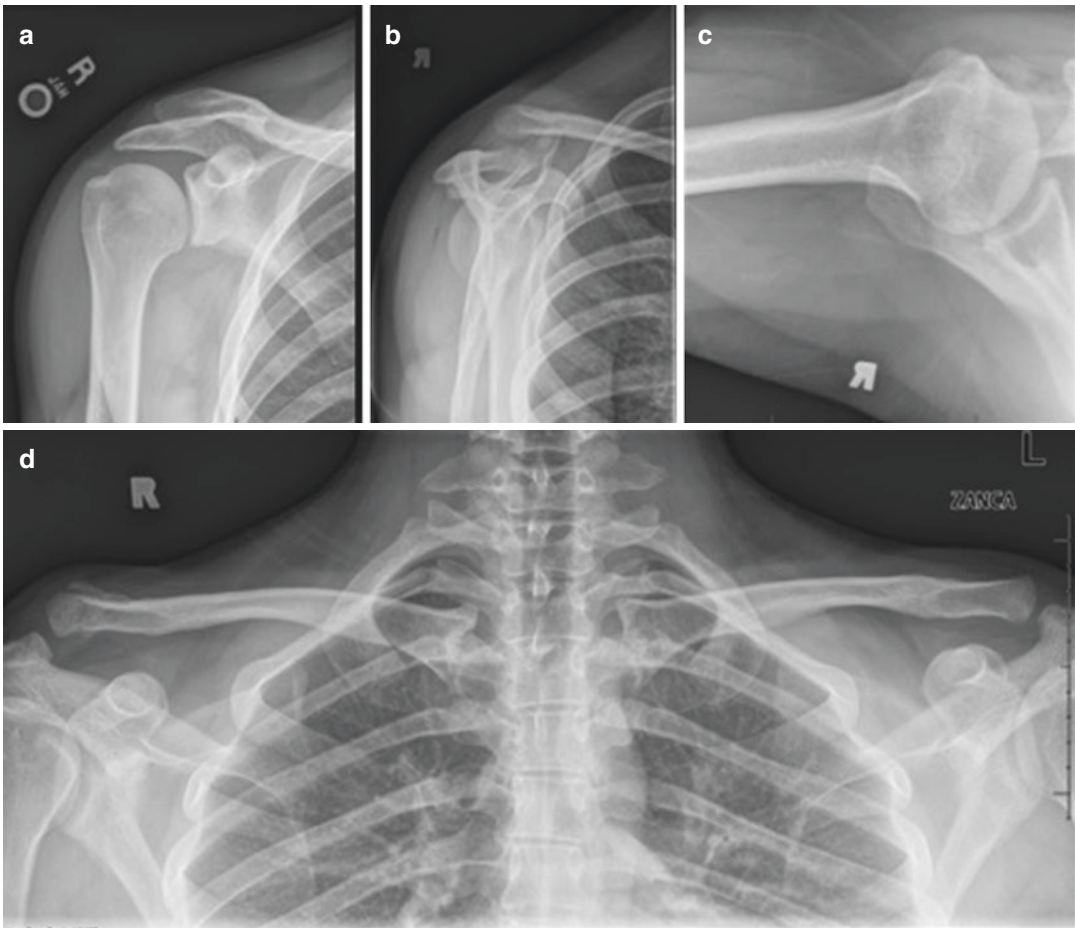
Standard radiographs. (a) Anteroposterior view, (b) scapular Y view, (c) axillary view, and (d) bilateral Zanca view
